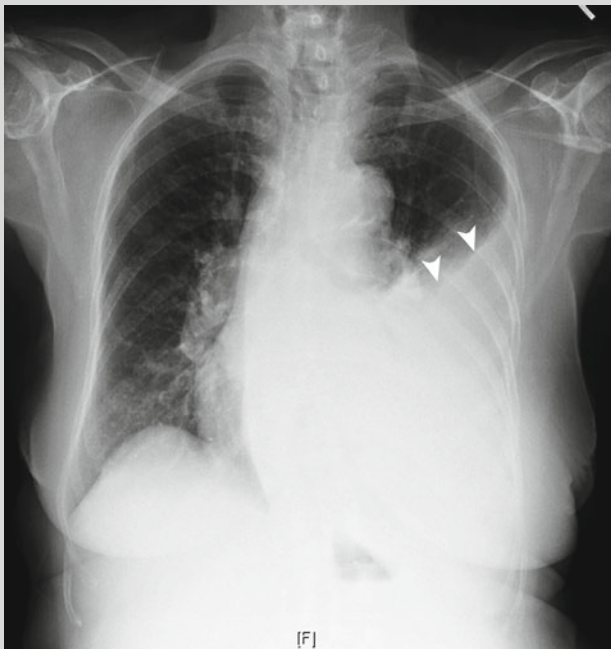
Frontal chest radiograph demonstrates moderate-sized left pleural effusion (*arrowheads*)
